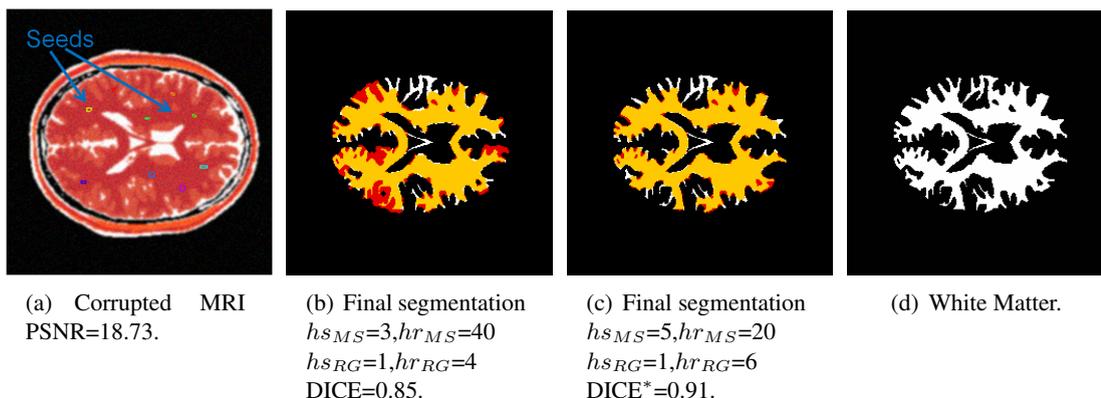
White matter segmentation of corrupted MRI image by using MS and RG.
